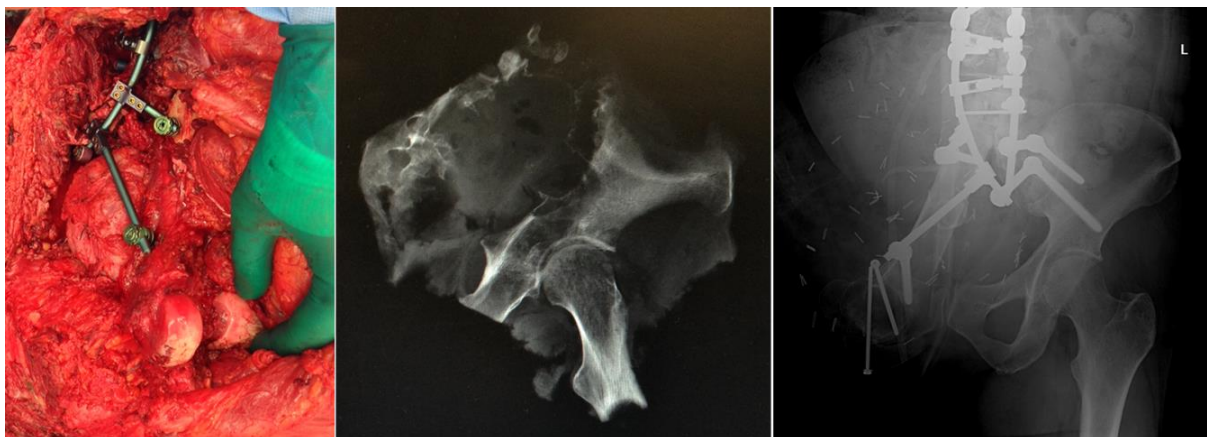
Intraoperative photograph of the vascularised femoral autograft, postoperative radiograph of the excised tumour, and postoperative patient radiograph
